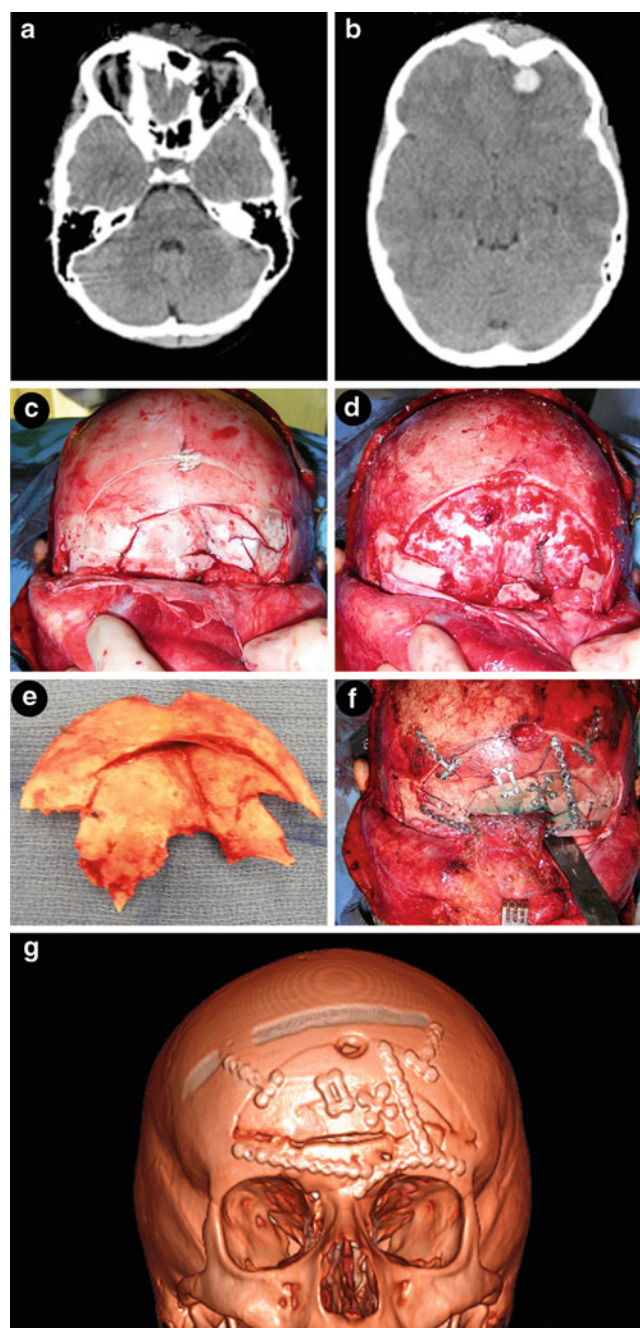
Representative pediatric patient who suffered a skull fracture after a blow to the head with a baseball. (a) CT image demonstrating a skull fracture involving the orbit and (b) an underlying contusion. (c) Intraoperative images demonstrating the skull fracture and (d) the dura after elevation of the fracture and repair of the dural tear. (e) Elevated fracture. (f) Intraoperative image after plating of the fracture. (g) Postoperative CT reconstruction
